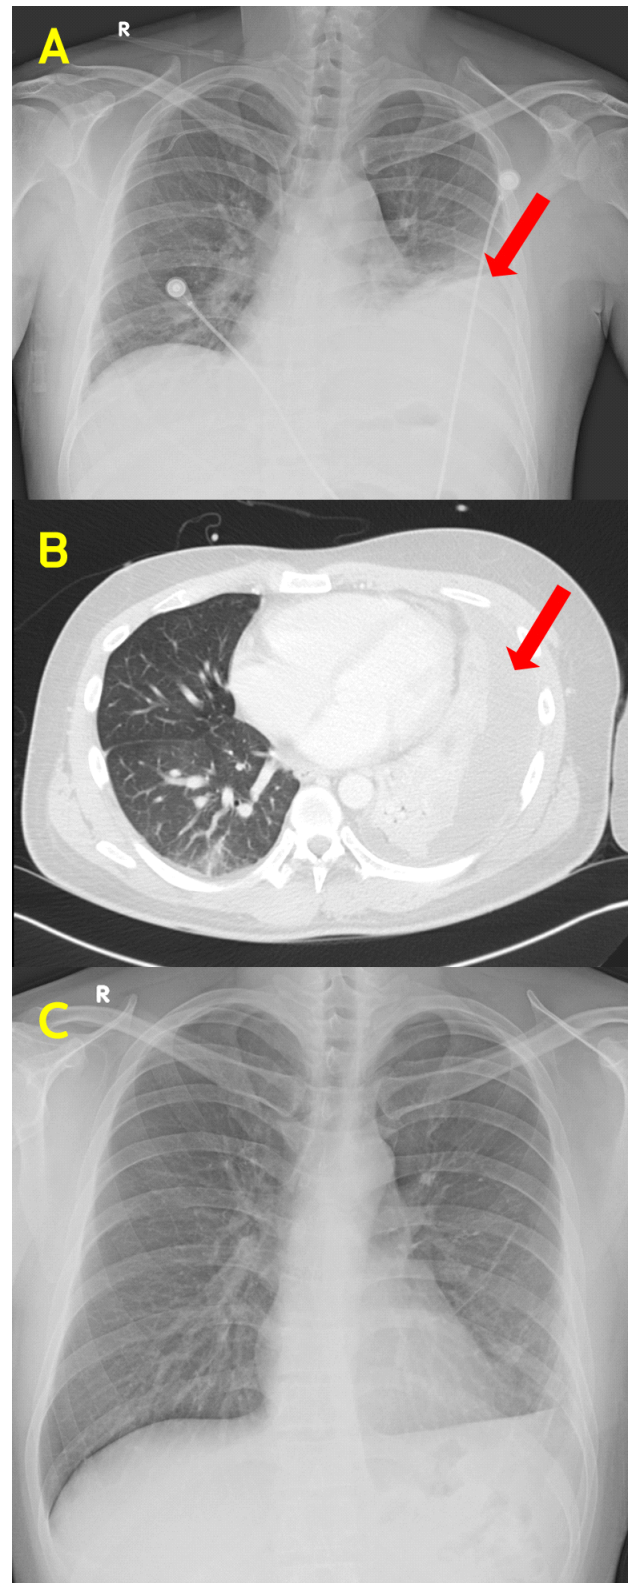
Chest X-ray and Computed tomography of chest. It shows empyema of left lung (arrow).
